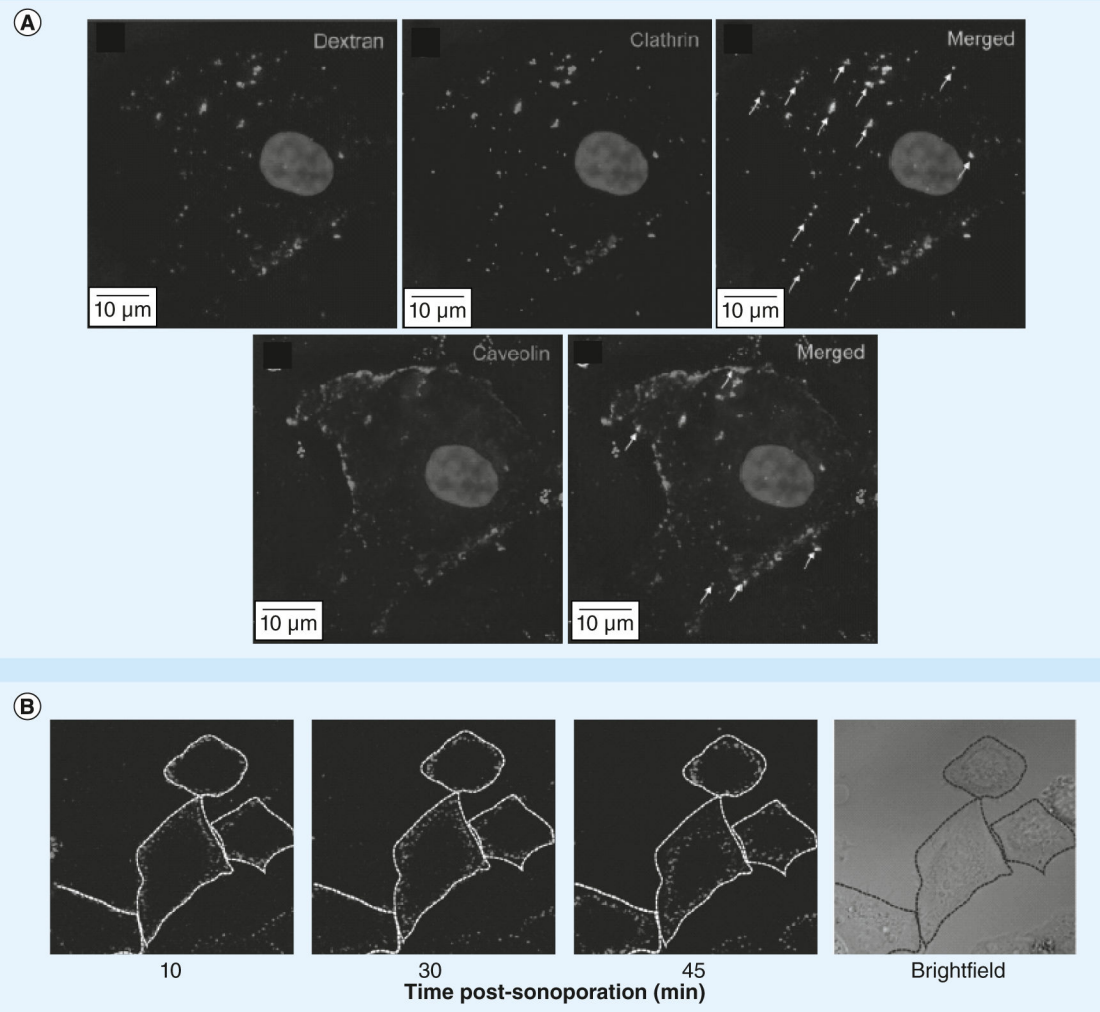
Large macromolecules may enter cells by endocytosis after ultrasound treatment (A) Co-localization of 500 kDa dextran and endocytosis markers (clathrin and caveolin) after sonoporation. (B) Fluorescent-labeled plasmid DNA distribution and trafficking at 10, 30 and 45 min after sonoporation show that the vesicles move closer to the nucleus over time.
